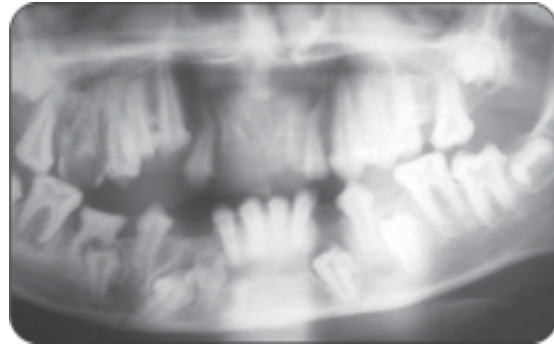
Radiograph of dentinogenesis imperfecta X-ray
